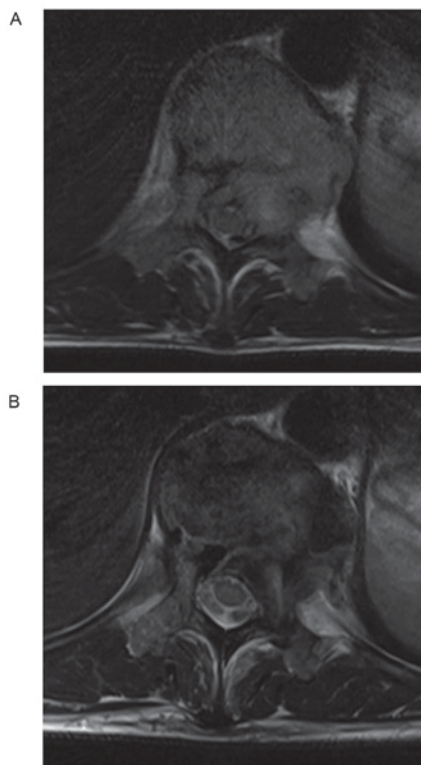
T2-weighted magnetic resonance images showing an axial view. (A) Prior to denosumab therapy. (B) At 8 months after denosumab therapy.
